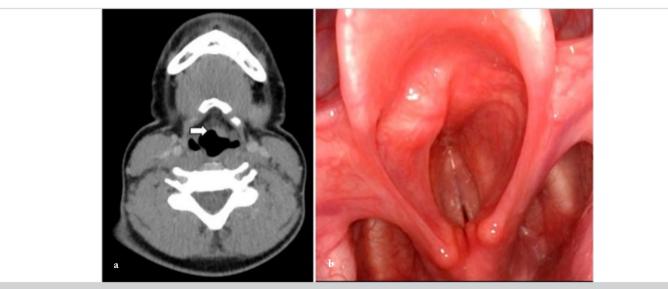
Fifth month recurrent tumor. a) Axial computed tomography with contrast showing a lesion of 5x5x8 mm with a moderate contrast enhancement in laryngeal epiglottic side (small white arrow); b) Endoscopic view of the recurrent lesion in outpatient control
